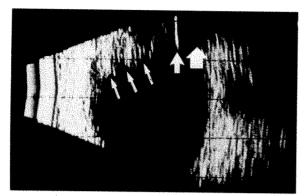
(Whitacre). Ultrasonogram of an eye with a single intraocular gas bubble after pneumatic retinopexy. The ultrasound probe was in line with the visual axis and the top of the screen corresponds to the top of the patient's head. The patient's head was tilted slightly backward, bringing the bubble into contact with the lens. A trail of fine reverberations from the gas-fluid and gas-tissue interface (small arrows) and a single reverberation from the gas interface and the transducer tip (medium arrow) was seen at full receiver gain. The reverberation from the transducer tip was seen at twice the distance between the far left-hand side of the tracing and the anterior face of the gas bubble (the small arrow at the far left). Posterior shadowing was present (large arrow).
